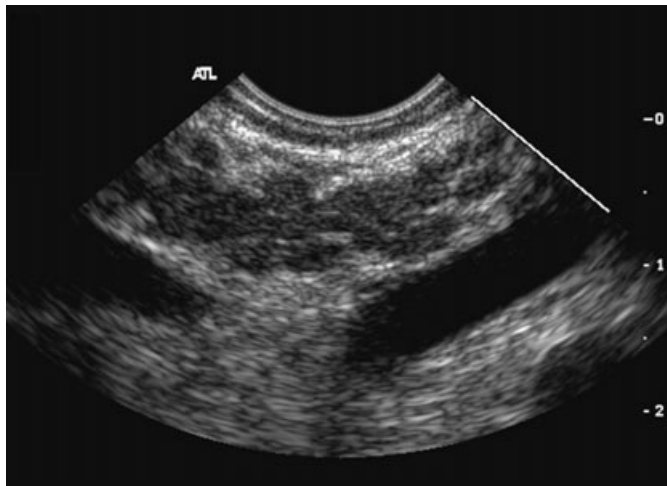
Characteristic endoscopic ultrasound finding of autoimmune pancreatitis demonstrating diffuse (sausage-shape) pancreatic enlargement with a hypoechoic, coarse, patchy, heterogeneous appearance.
